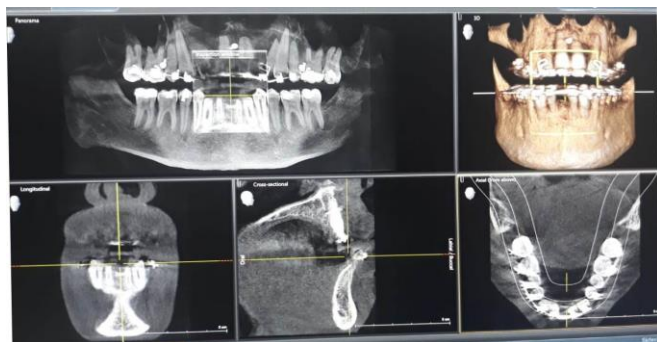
Pre debond CBCT scan.
